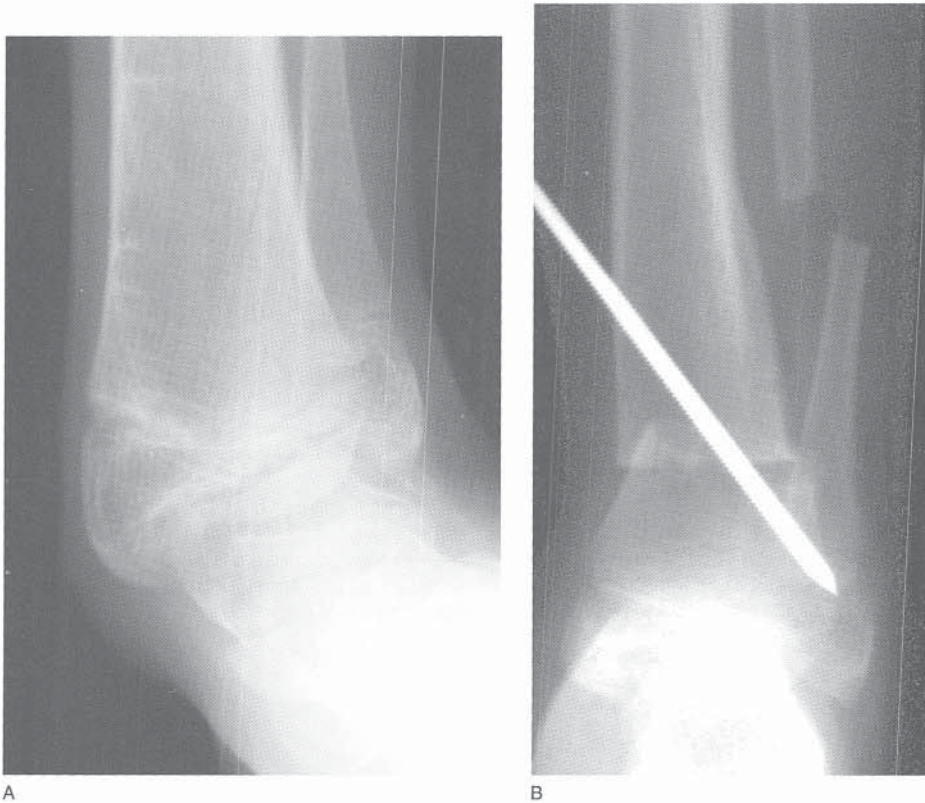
Distal tibial osteotomy for ankle valgus. A, Preoperative radiographic appearance. B, Postoperative radiographic appearance. Note displacement of the distal fragment laterally to prevent excessive prominence of the medial malleolus. The fibular osteotomy should be placed as distally as possible to prevent excessive prominence of the distal fragment on the lateral side of the ankle.
